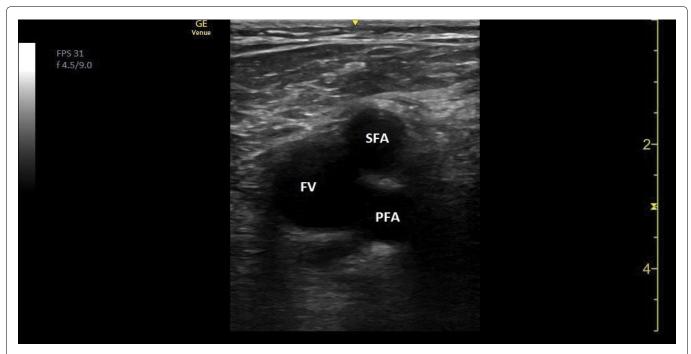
Ultrasound image showing the left femoral vein (FV) and the superficial (SFA) and profound (PFA) femoral artery.
